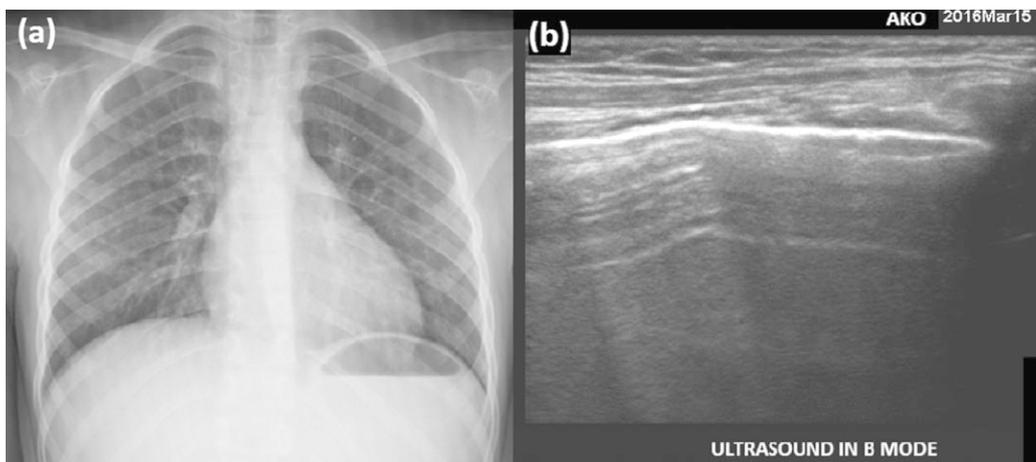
The previous radio-opaque appearance is no longer visible at control posterior-anterior chest X-ray (a) and there is no area compatible with atelectasis at control lung ultrasonography evaluation (b).
